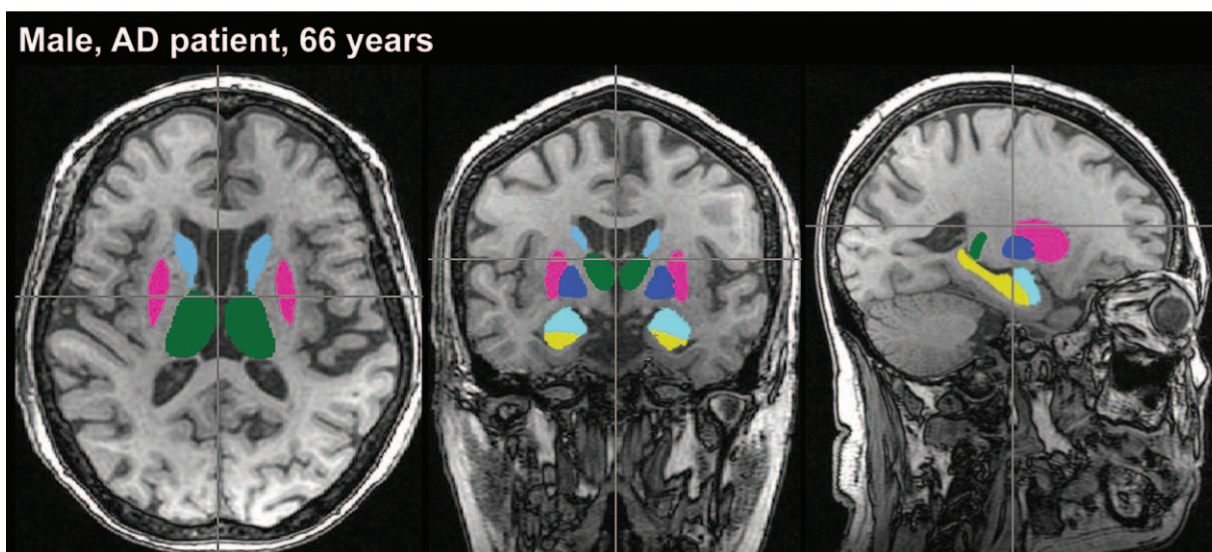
Example of automated segmentation of subcortical gray matter structure using FIRST in AD patient. Segmentations are shown overlaid on the 3D T1-weighted images in 3 orthogonal orientations, corresponding to the axial (left column), coronal (middle column), and sagittal (right column) planes. Colored structures—yellow: Hippocampus; Turquoise: Amygdala; Green: Thalamus; Light blue: Caudate nucleus; Pink: Putamen; Dark blue: Globus pallidus; Orange: Nucleus accumbens. AD=Alzheimer's disease.
